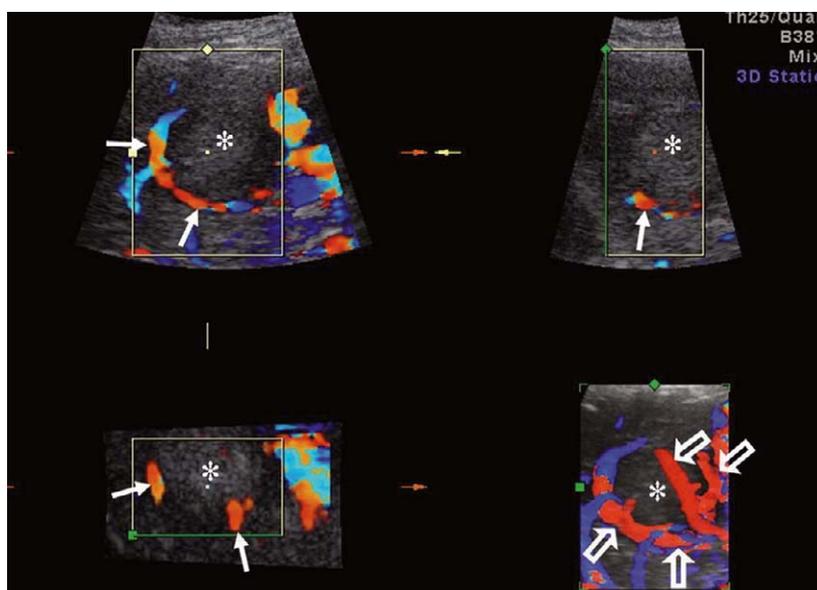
Three-dimensional (3D) color Doppler ultrasound image of large hepatocellular carcinoma in a 55-year-old woman. Transverse (top left), sagittal (top right) and coronal (bottom left) images of left hepatic lobe demonstrate hypervascularity around the low echoic tumor (*). 3D color Doppler image rendered by maximum intensity projection mode (bottom right) demonstrates multiple feeding arteries (open arrows) from the left lower portion of the tumor (*), showing the basket pattern.
